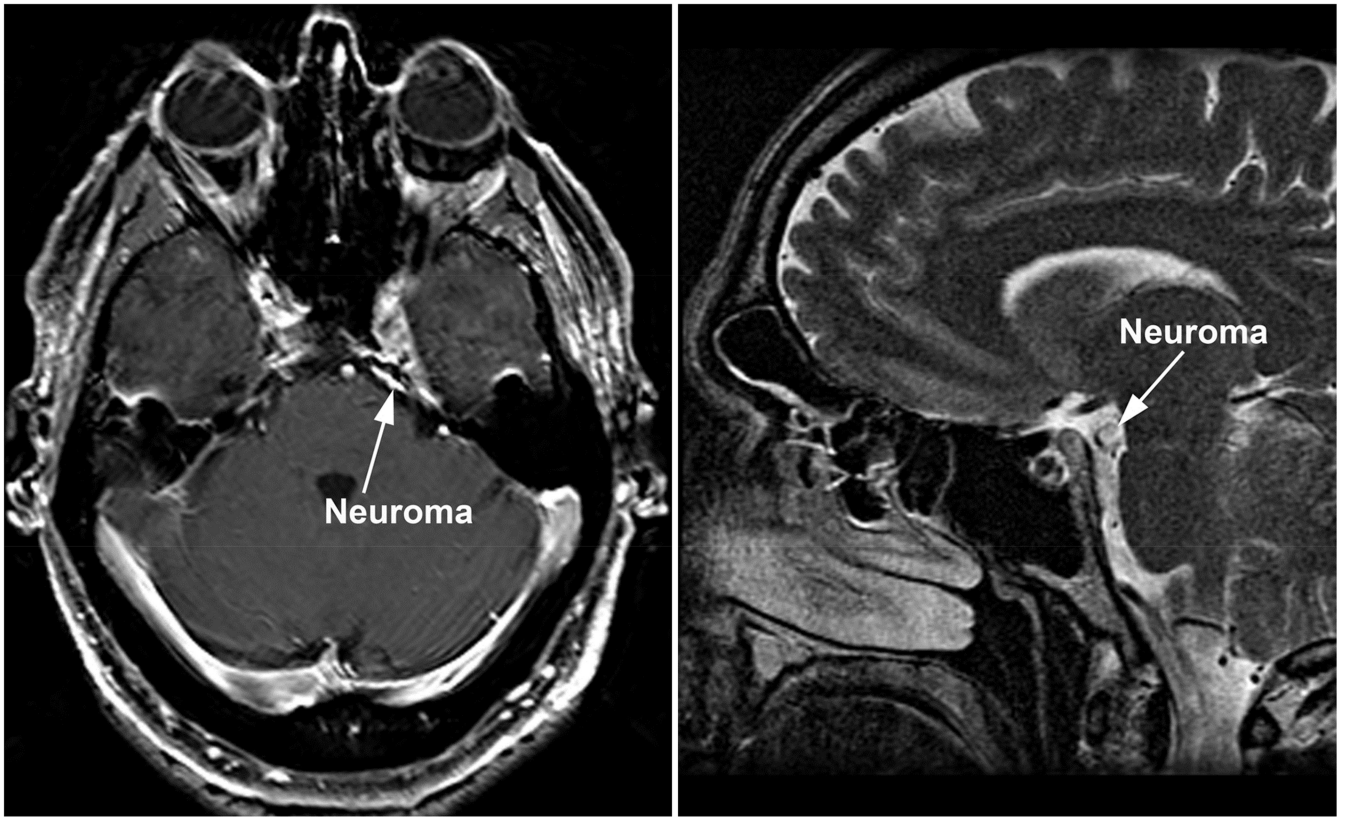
Gadolinium enhanced, axial T1 MRI demonstrating a large, enhancing neuroma of Case 7 located in left cavernous sinus and subarachnoid space.
